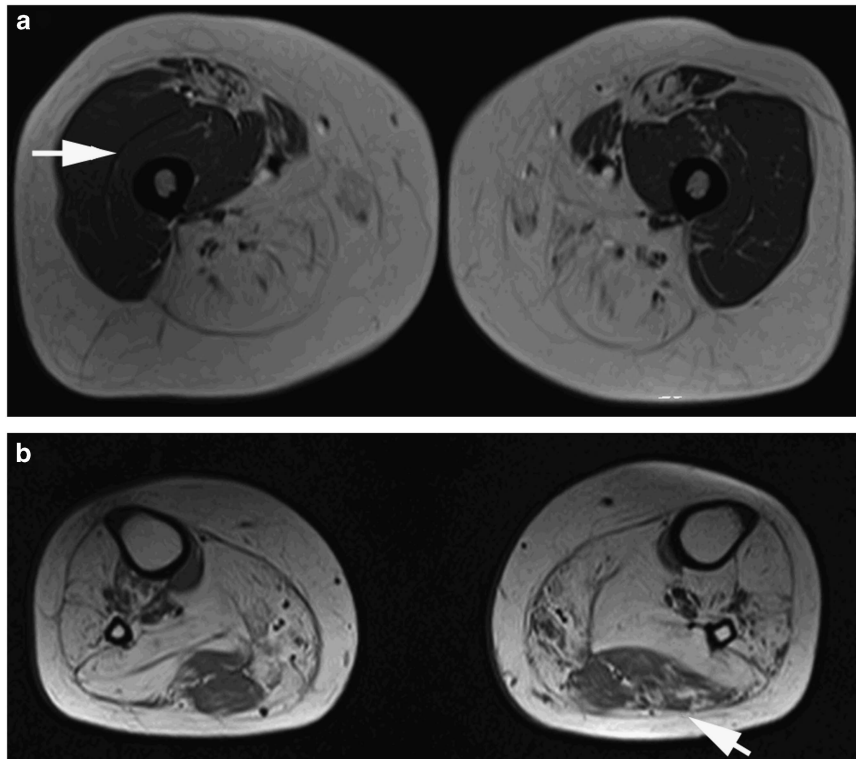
Thighs (a) and legs (b) T1-weighted MR images (patient 7b). (a) Atrophy and fat replacement of posterior thigh muscles with relative sparing of quadriceps (white arrow) and sartorius muscles. (b) Fatty replacement in anterior and posterior leg muscles with relatively less involvement of the lateral head of gastrocnemius muscle (white arrow).
